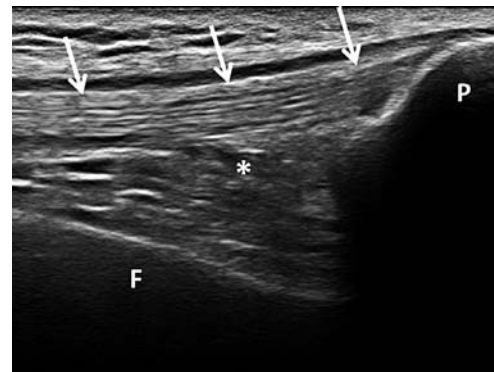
Ultrasound of the knee in a healthy individual. Longitudinal anterior scan at the suprapatellar recess level. Normal quadriceps tendon (↑) and normal amount of synovial fluid (*) are visualized. F: femur; P: patella
